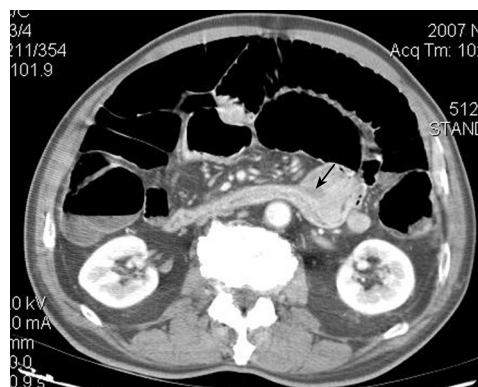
CT showing a mass on the fourth part of the duodenum (arrow).
